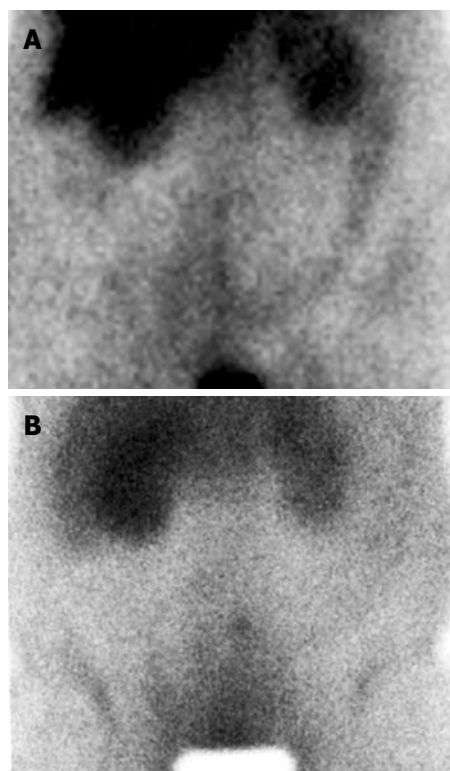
Anterior Tc-99m (V) DMSA scintigram in a patient with ischemic colitis: Moderate uptake of the radiotracer in the splenic flexure and the descending colon (A) and no uptake of the radiotracer in the bowel (B).
